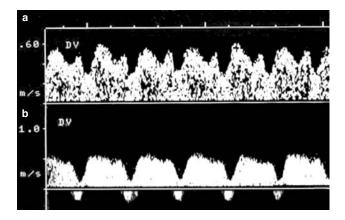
Pulsed Doppler waveforms from the ductus venosus. (a) Normally grown twin characterized by forward flow throughout the cardiac cycle with high velocity during ventricular systole and diastole; and (b) recipient with signs of congestive heart failure in twin-to-twin transfusion syndrome. Note the presence of reversed blood flow during atrial contractions
